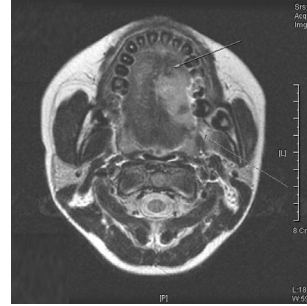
Preoperative MRI of a 21-year-old woman with biopsy-proven squamous cell carcinoma shows an approximately 4cm ulcerating mass on the left side of the tongue (arrow).
